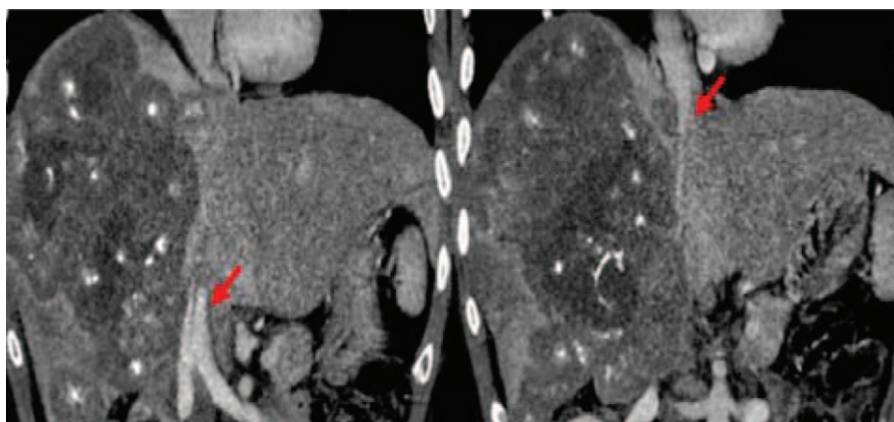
A CT scan of the upper abdomen of an HAE patient. Red arrows show that the alveolar hydatid lesions are involved the IVC. CT = computed tomography, HAE = hepatic alveolar echinococcosis, IVC = inferior vena cava.
